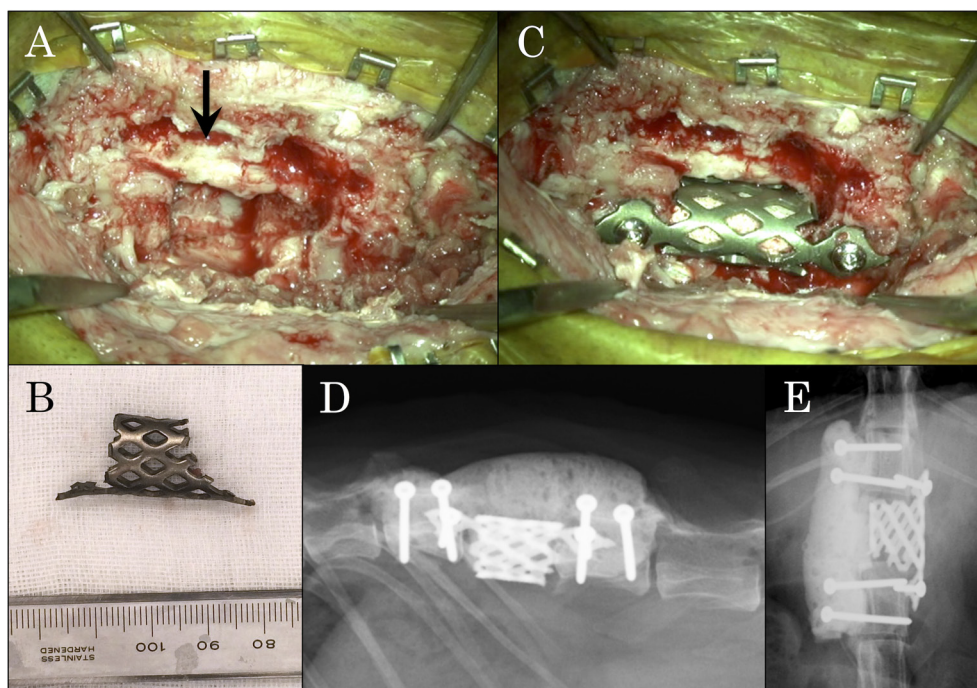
Vertebrectomy performed at the third surgery. The spinal cord (arrow) was fully exposed after the removal of all components of the L1 vertebra (A). Pyramesh cage (B) filled with β -Tricalcium phosphate was inserted and secured by 2.0 mm cortical screws to the vertebral body of T13 and L2 (C). Postoperative radiographs confirmed that the positioning of the cage and alignment of the cage with the adjacent vertebrae were considered appropriate (D, E).
